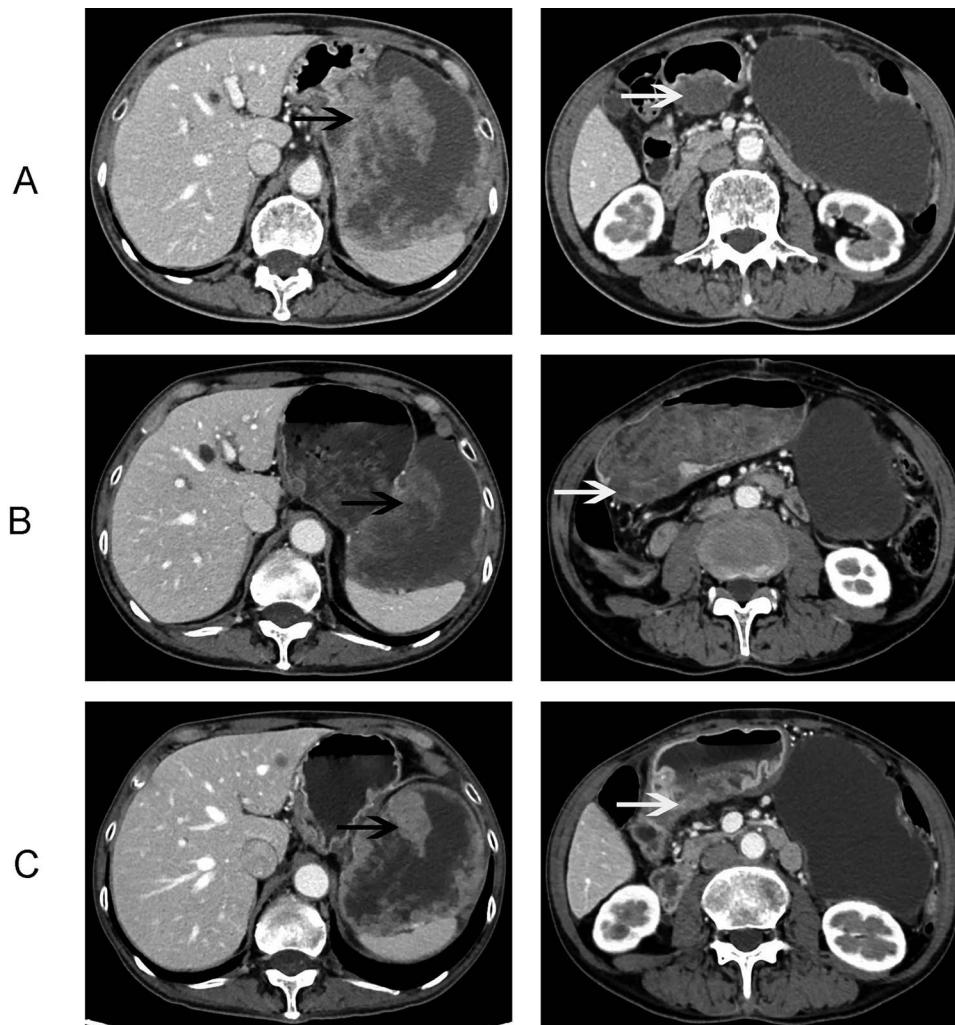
Apatinib treatment reduced the tumor volume of gastrointestinal stromal tumor and synchronous gastric cancer. Abdominal computed tomography scans showing a huge mixed echogenic GIST (black arrow) and the gastric cancer (white arrow) before apatinib treatment (A) to a partial response (B), and continuous PR (C) in the last two routine follow-up visits. The tumor density of the GIST was also dramatically reduced after apatinib treatment.
